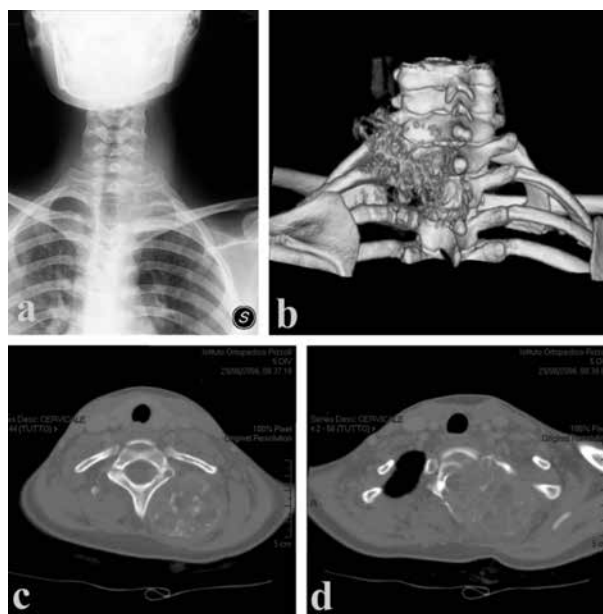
(a) AP radiograph. (b) CT three-dimensional reconstruction. (c) and (d) osteolytic expansile lesion involving pedicles, laminae, and spinous process of T2, extending to the paravertebral area C4-T5.
